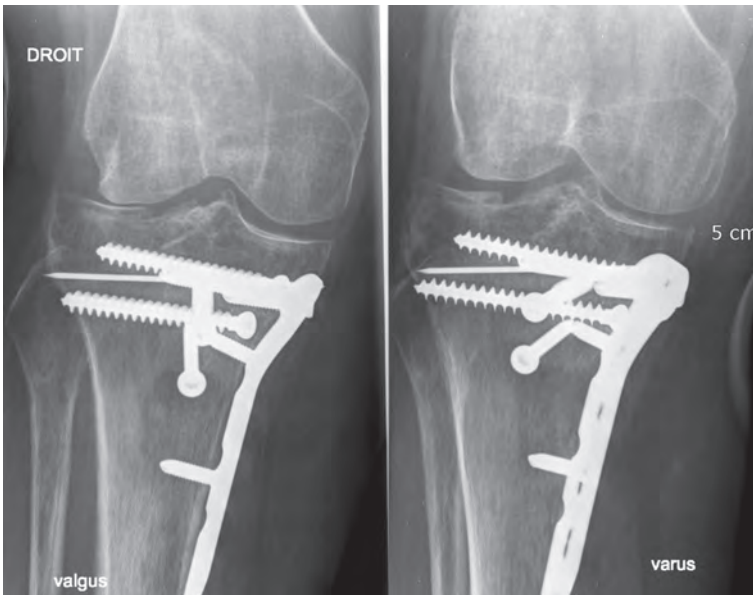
Lateral post-traumatic OA. Reducibility of the deformity is shown on varus stress X-ray (right) and absence of concomitant medial laxity is assessed on valgus stress view (left).
